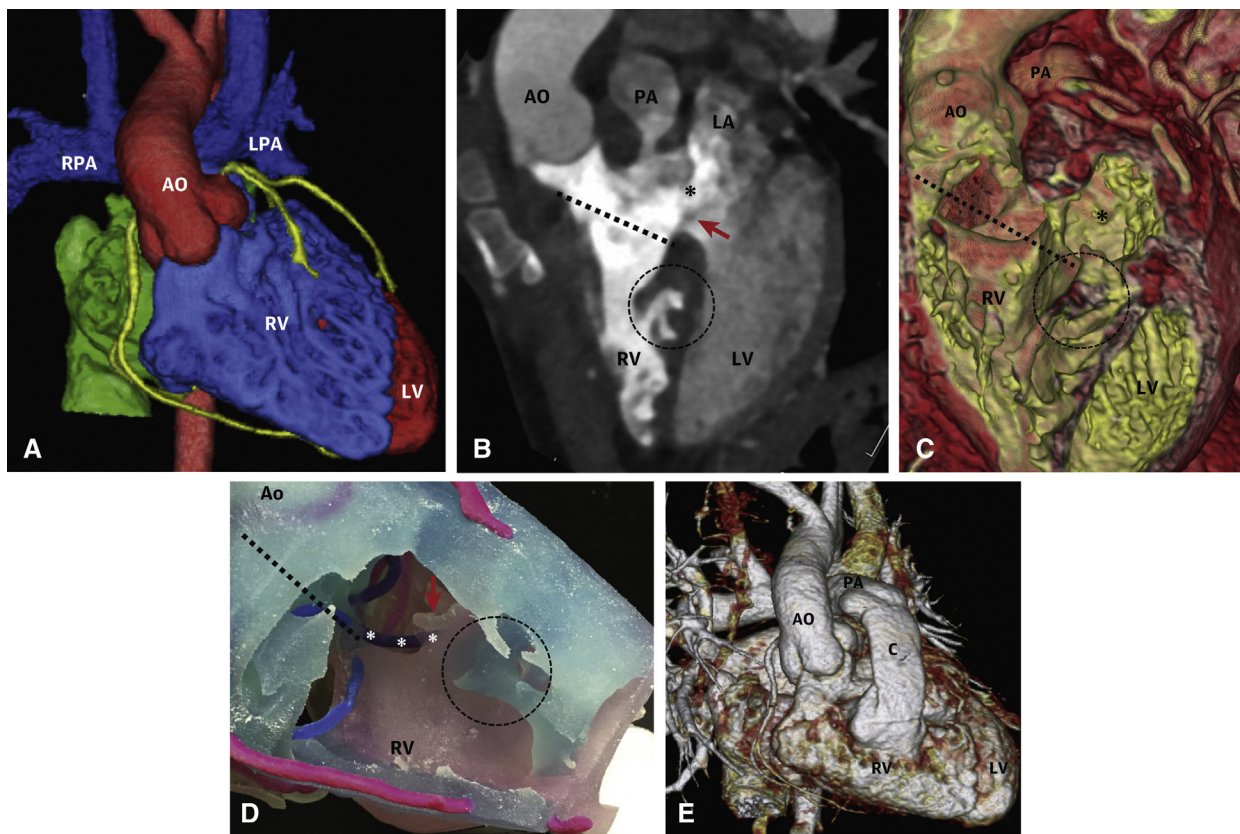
Double-outlet right ventricle in 35-month-old boy. A to C, Preoperative CT images showing double-outlet right ventricle with ventriculoseptal defect (asterisks) and straddling of the mitral valve (red arrow). The dotted line measures the distance between the ventriculoseptal defect and the aortic annulus, which before 3D modeling was deemed too difficult for biventricular repair and palliative strategy was planned. D, The 3D model demonstrating the suturing margin along the VSD (asterisks on a purple ring). Visualization of this margin and distance changed the approach to biventricular repair with VSD baffling. E, Postoperative CT shows successful VSD baffling and RV to PA conduit. RPA, Right pulmonary artery; LPA, left pulmonary artery; AO, aorta; PA, pulmonary artery; LA, left atrium; RV, right ventricle; LV, left ventricle. Reprinted with permission from Yang and colleagues.³¹
